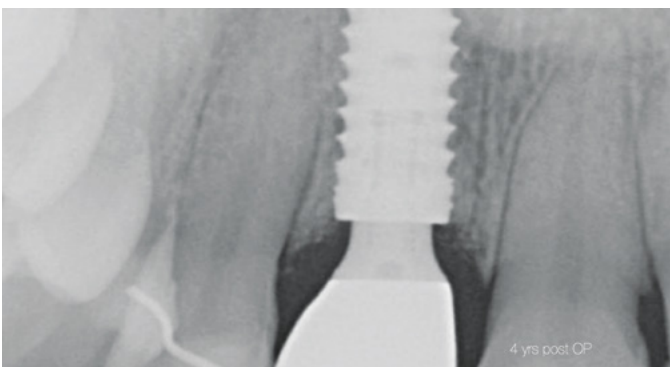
Periapical radiograph showing implant integration a 4 year post-surgery result
